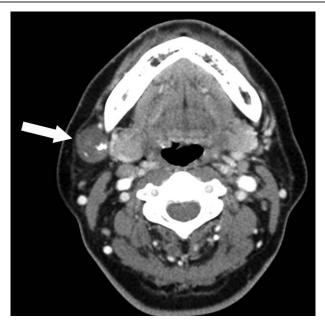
Neck CT scans show a 2.1 cm sized well-defined, poorly enhancing mass (arrow) with calcification in the right parotid space, without invasion of the adjacent structures.
